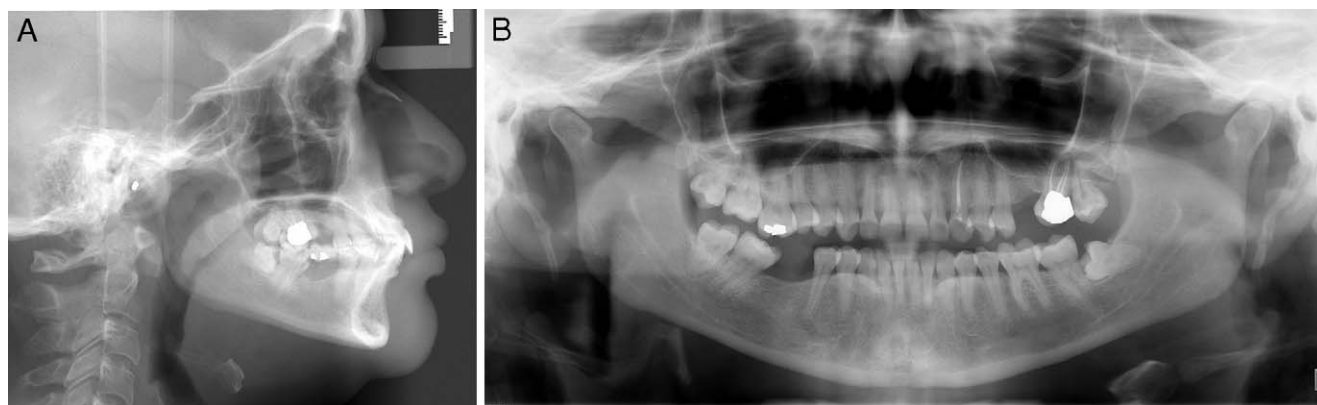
(A) Pretreatment lateral cephalograph. (B) Pretreatment panoramic radiograph.
